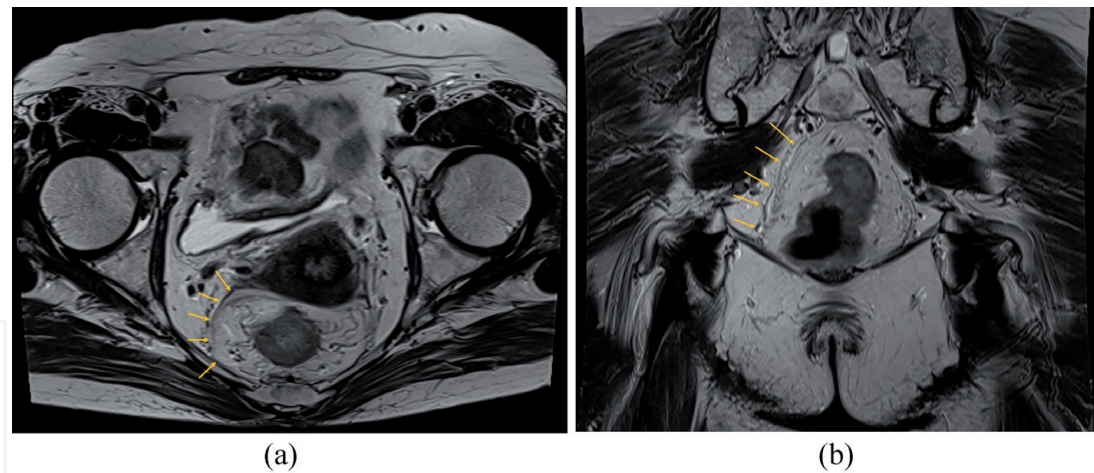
Magnetic resonance image scan. Magnetic resonance image scan (MRI) can clearly show the boundaries of these mesorectum and mesorectal fascia. (a) T2 weighted image on MRI. Axial view. The rectum and mesorectum are enveloped by the fascia propria of the rectum (mesorectal fascia). (b) T2 weighted image on MRI. Coronal view. Mesorectum, mesorectal fascia, and puborectalis muscle.
